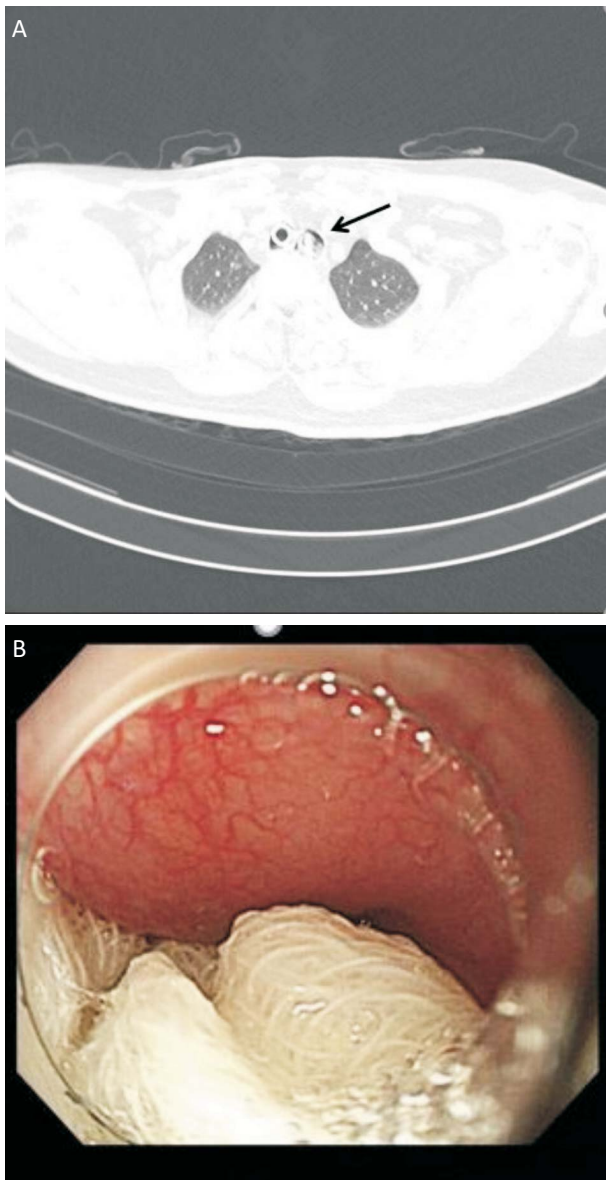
(A) Chest computed tomography: a foreign body in the upper esophagus (arrow). (B) Endoscopy: a foreign body (gauze) in esophagus.
